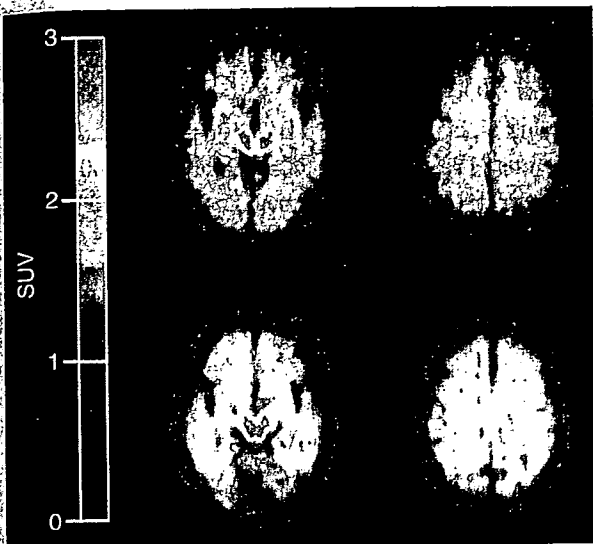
BF227-PETのSUV画像(口絵94参照)
